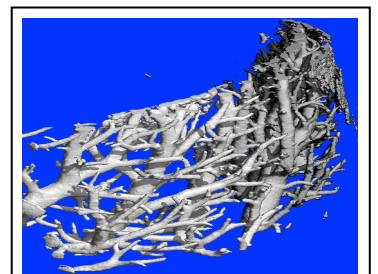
Vascular trees extracted from μ CT based angiograms.
